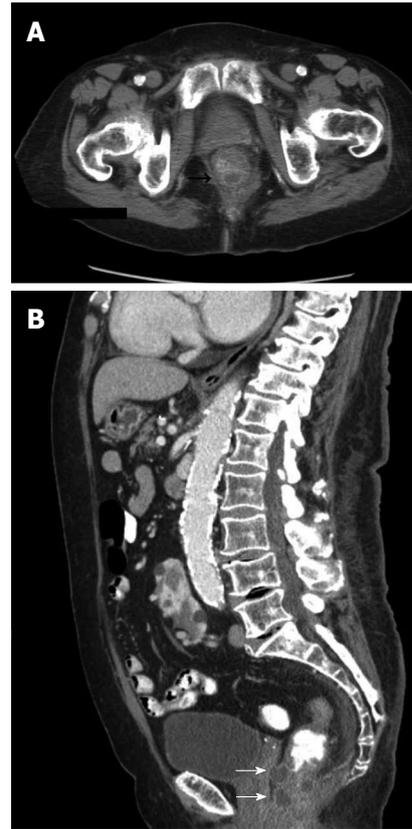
Computed tomography scan. A: Computed tomography scan axial view showing mural thickening with multiple rounded hypodense foci within the posterior rectal wall; B: Computed tomography scan sagittal view showing multiple rounded foci within the anterior and posterior rectal wall (white arrows).
